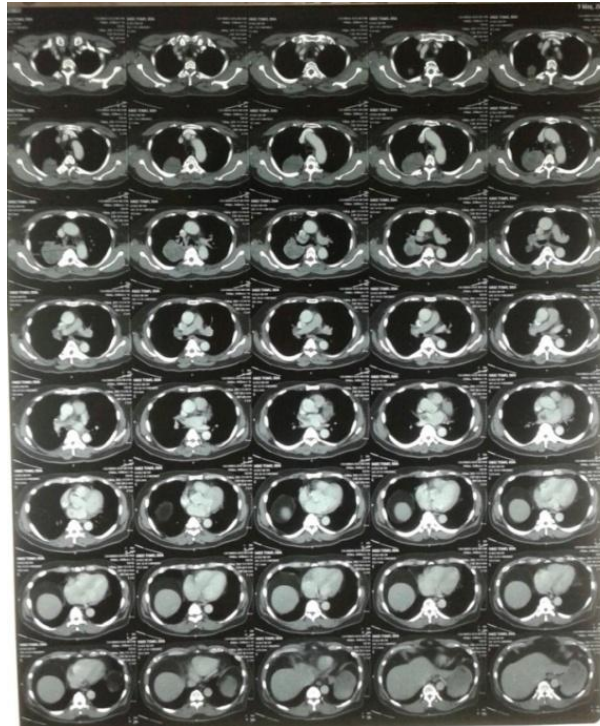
CT-Scan Thorax with contrast media
